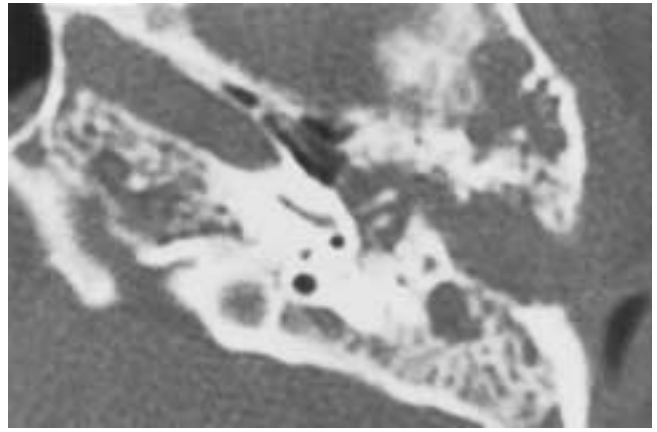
EAC and middle ear squamous cell carcinoma. Axial CT. There is ill-defined destruction of the anterior and posterior walls of the EAC and the lateral wall of the protympanum. The tumor is indistinguishable from adenoid cystic carcinoma or adenocarcinoma.
